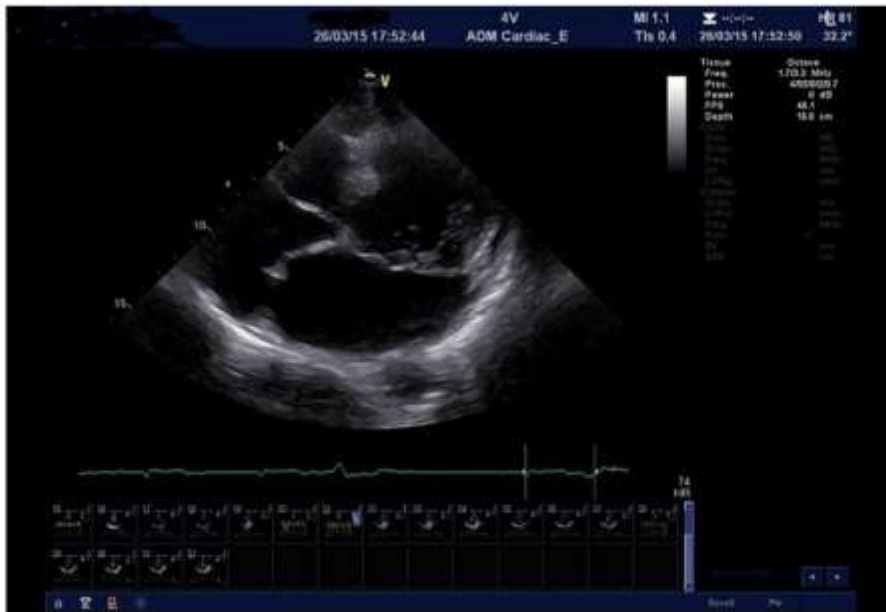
Trans-thoracic, two-dimensional echocardiographic image demonstrating prolapse of both the anterior and posterior mitral valve leaflets with an interatrial septal aneurysm which bulges into the right atrium.
